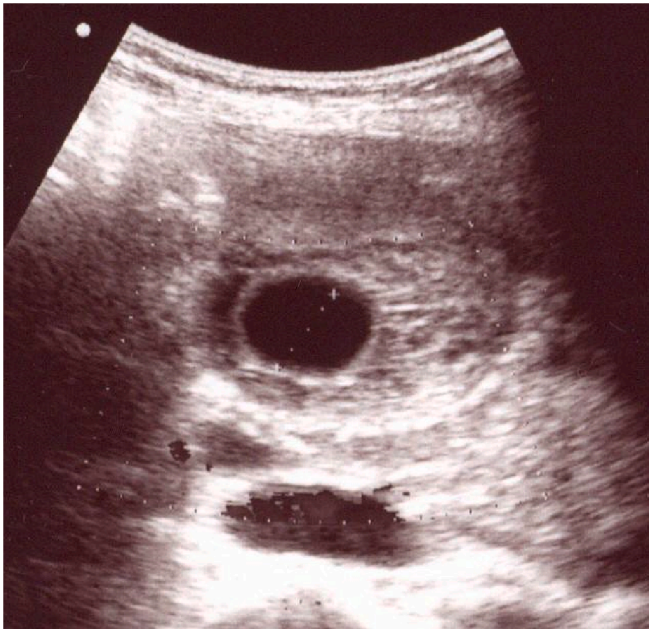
Transabdominal ultrasound shows gallbladder wall thickening.
